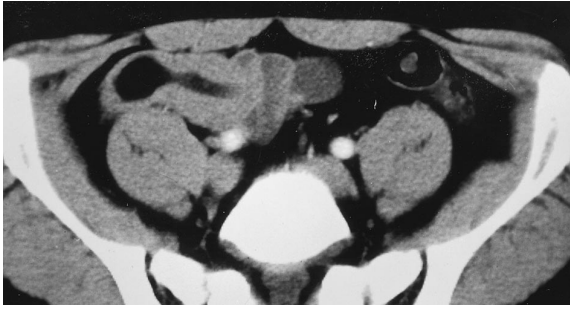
Contrast-enhanced CT shows the characteristic “target lesion” in the right lower quadrant, indicating an intussusception. Retrospectively, Meckel’s diverticulum presents as a hypodense intraluminal mass containing intraluminal air.
